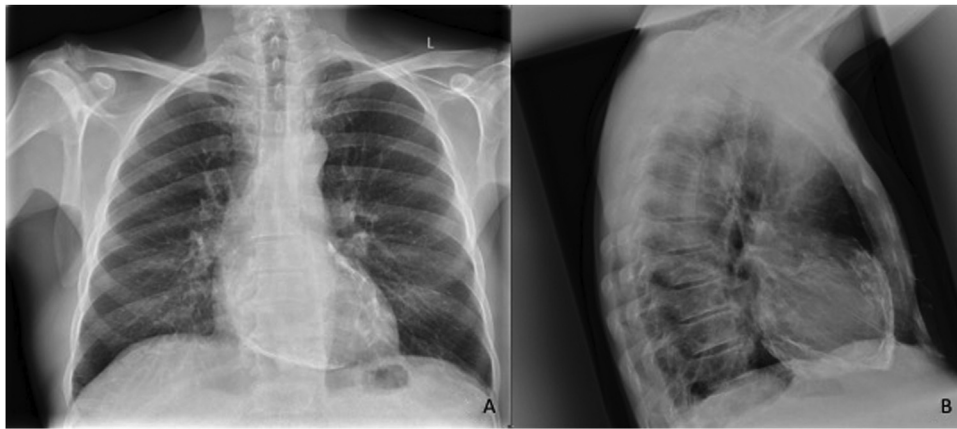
(A): PA Chest X-ray showing mild to moderate pericardial calcification (B): Lateral Chest X-ray showing more extensive pericardial calcification.
